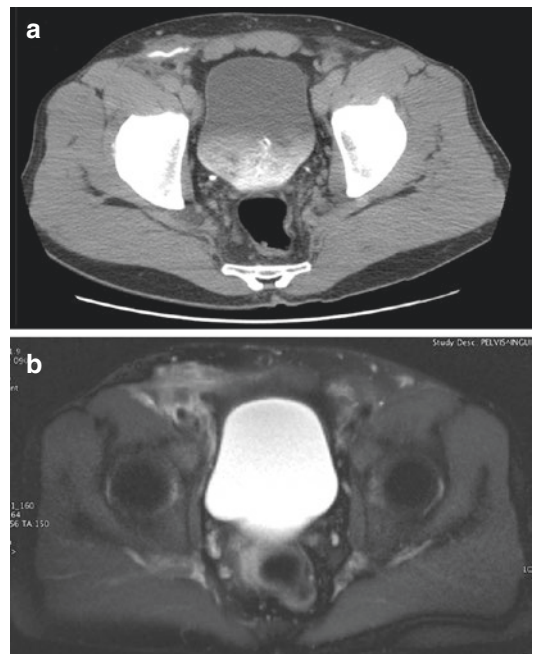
CT (a) and MRI (b) pelvis of the same patient with infected right groin mesh. CT shows ePTFE mesh very distinctly bright. The surrounding soft tissue was interpreted on CT as “normal postoperative changes.” MRI correctly identified the soft tissue as inflamed and thus diagnosed a mesh infection
